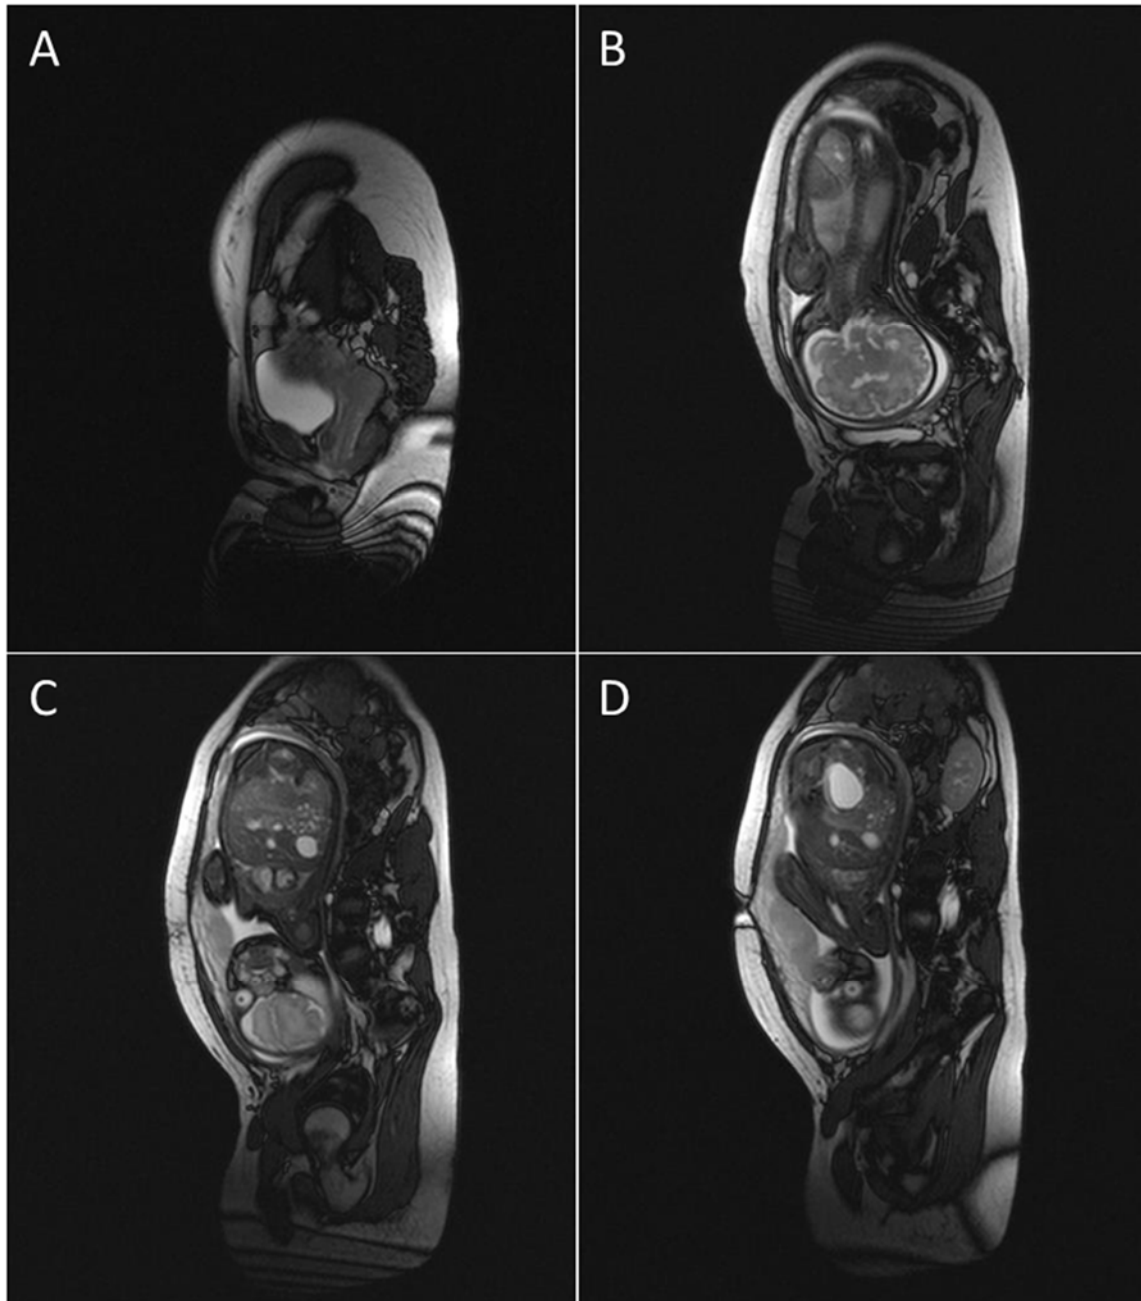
Sagittal Plane MRI Scans of Human Pregnancy
